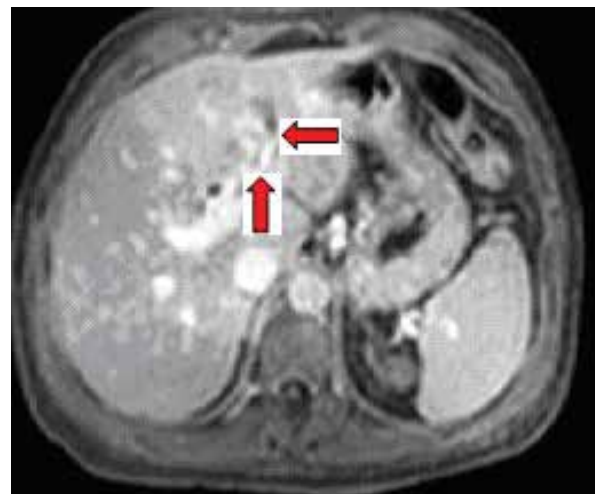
Magnetic resonance imaging of the abdomen showing venous thrombosis in the left portal vein
